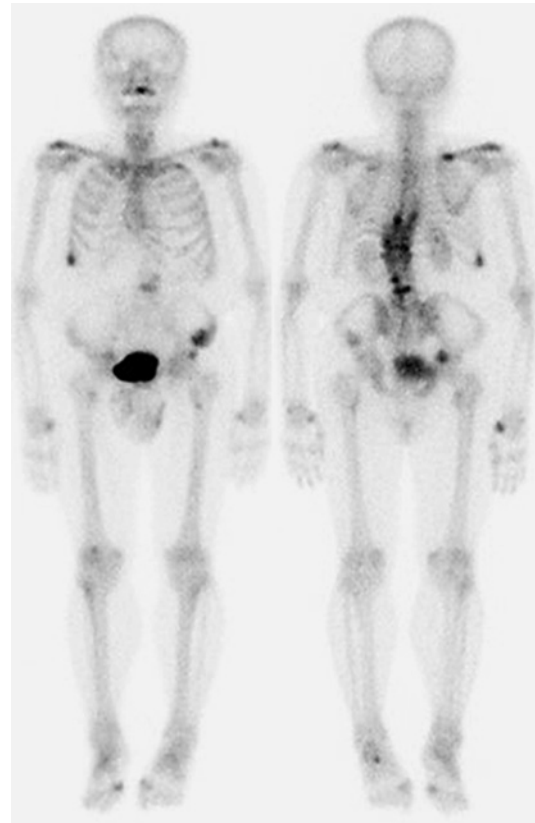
Initial ^{99m}Tc bone scintigraphy at the time of prostate cancer diagnosis. Whole-body ^{99m}Tc bone scintigraphy showed abnormal uptakes in the bilateral femur, the bilateral scapula, and right rib, suggesting multiple bone metastases, and uptakes in the thoracic vertebra, reflecting nonspecific accumulation for the bone spicule.
